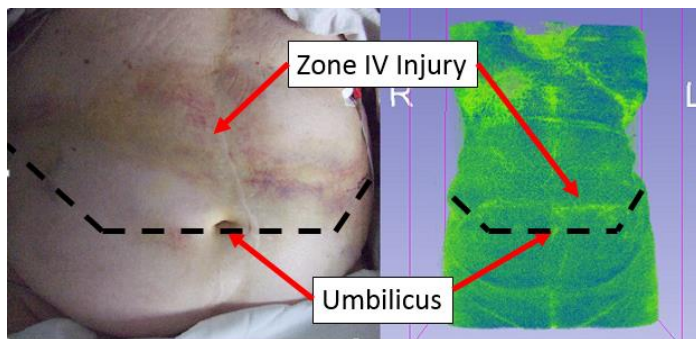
Example of zone determination for an occupant photo and CT three-dimensional rendering.
